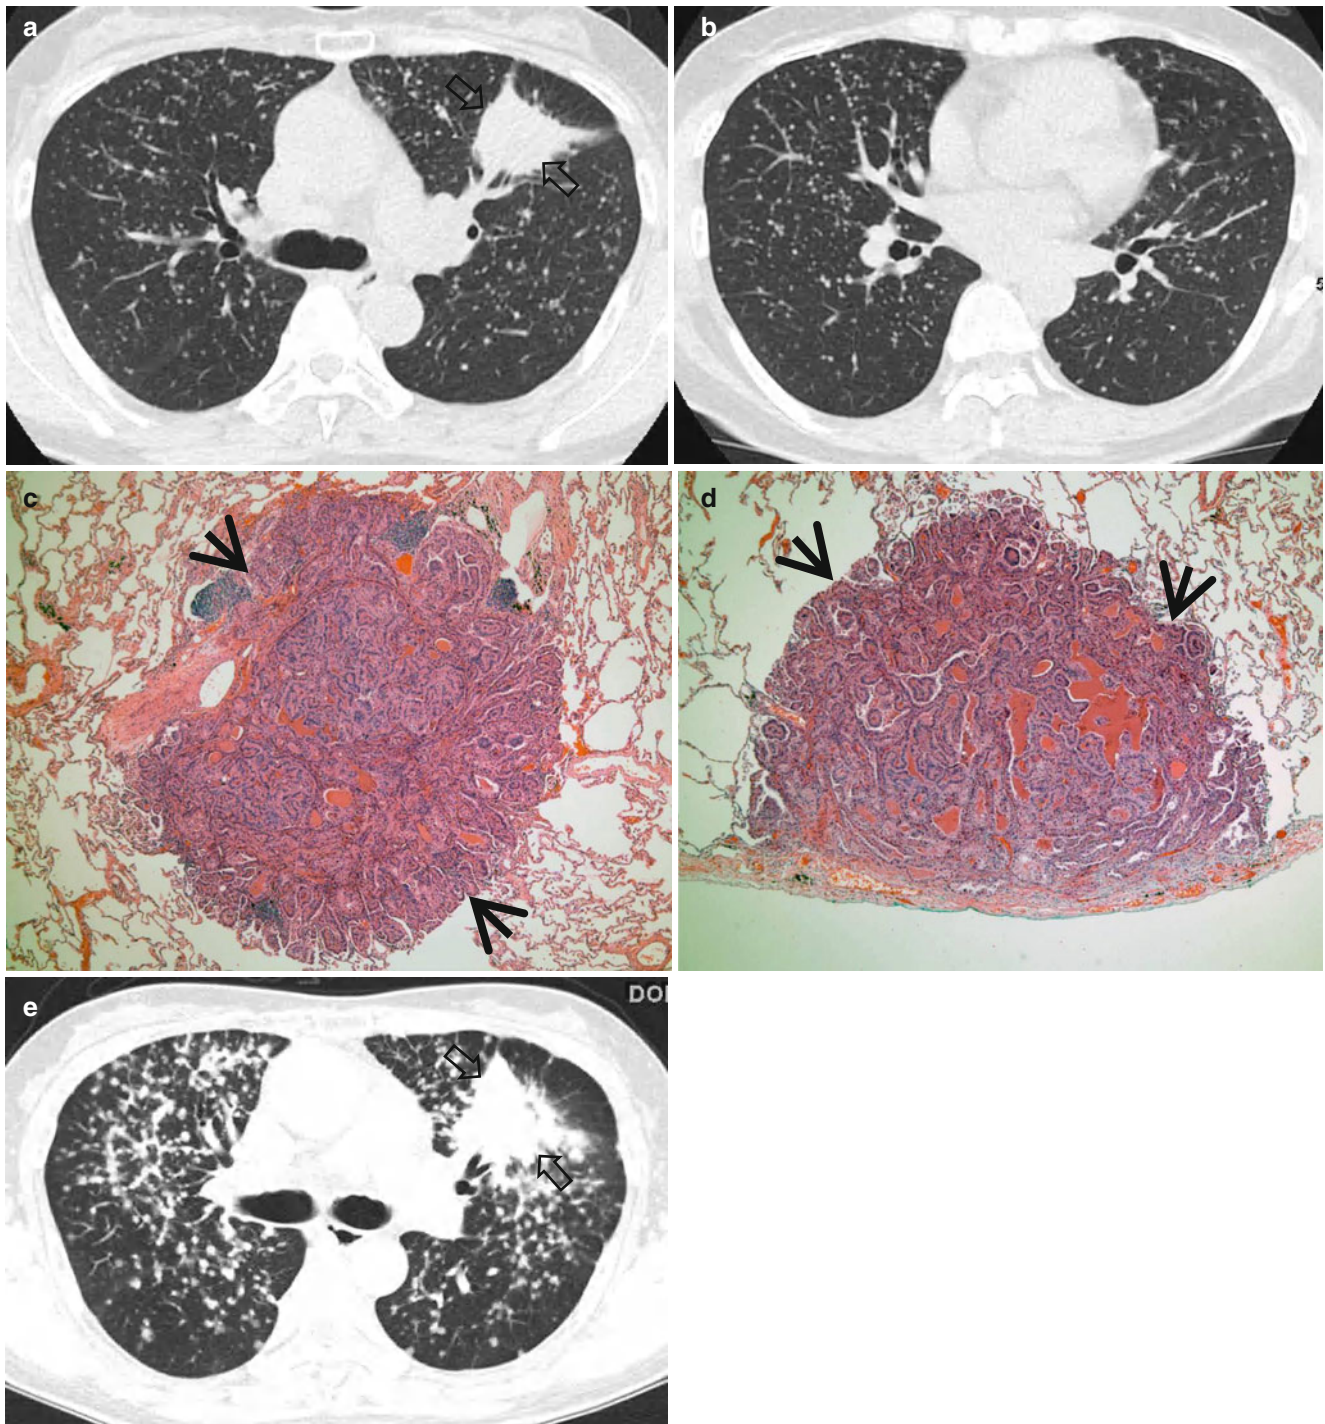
Miliary metastases in a 60-year-old woman who has lung adenocarcinoma. (a, b) Lung window images of CT (2.5-mm section thickness) scans obtained at levels of right upper lobar bronchus (a) and basal trunk (b), respectively, show a primary lung cancer (*open arrows*) in the left upper lobe and randomly distributed innumerable small nodules in both lungs. Also note diffuse ground-glass opacity in background lungs.
